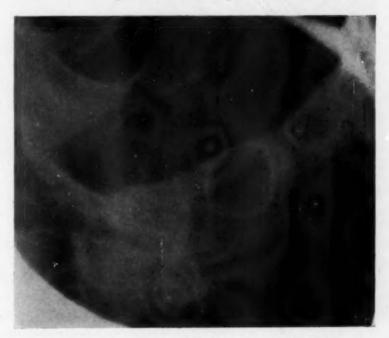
X-ray of mandible showing cyst on right.
